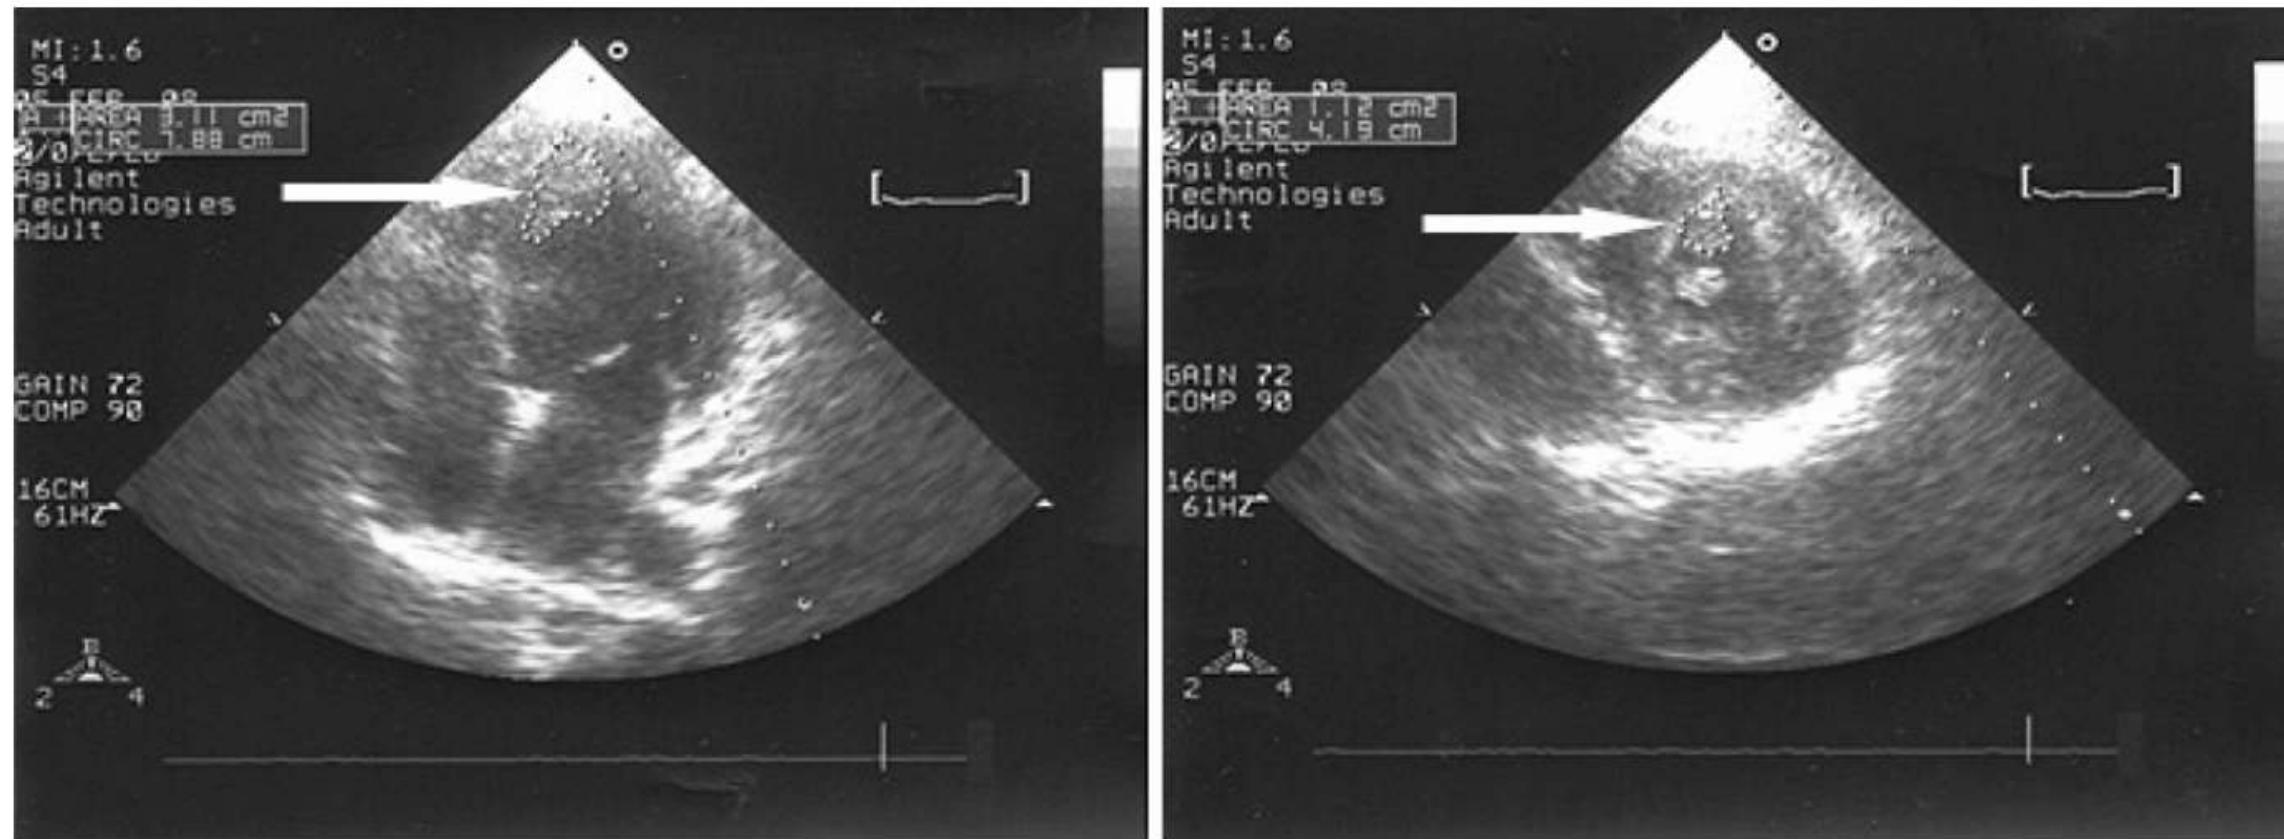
Two-dimensional cardiac echocardiogram. Left, Four chambers view. Right, Parasternal transversal view of a section at the level of papillary muscles. Thrombus presence is indicated by white arrows.
